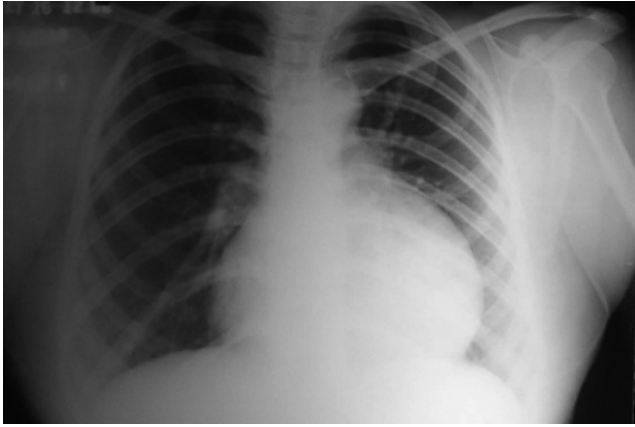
Preoperative chest x-ray (left) and MRI (right).
